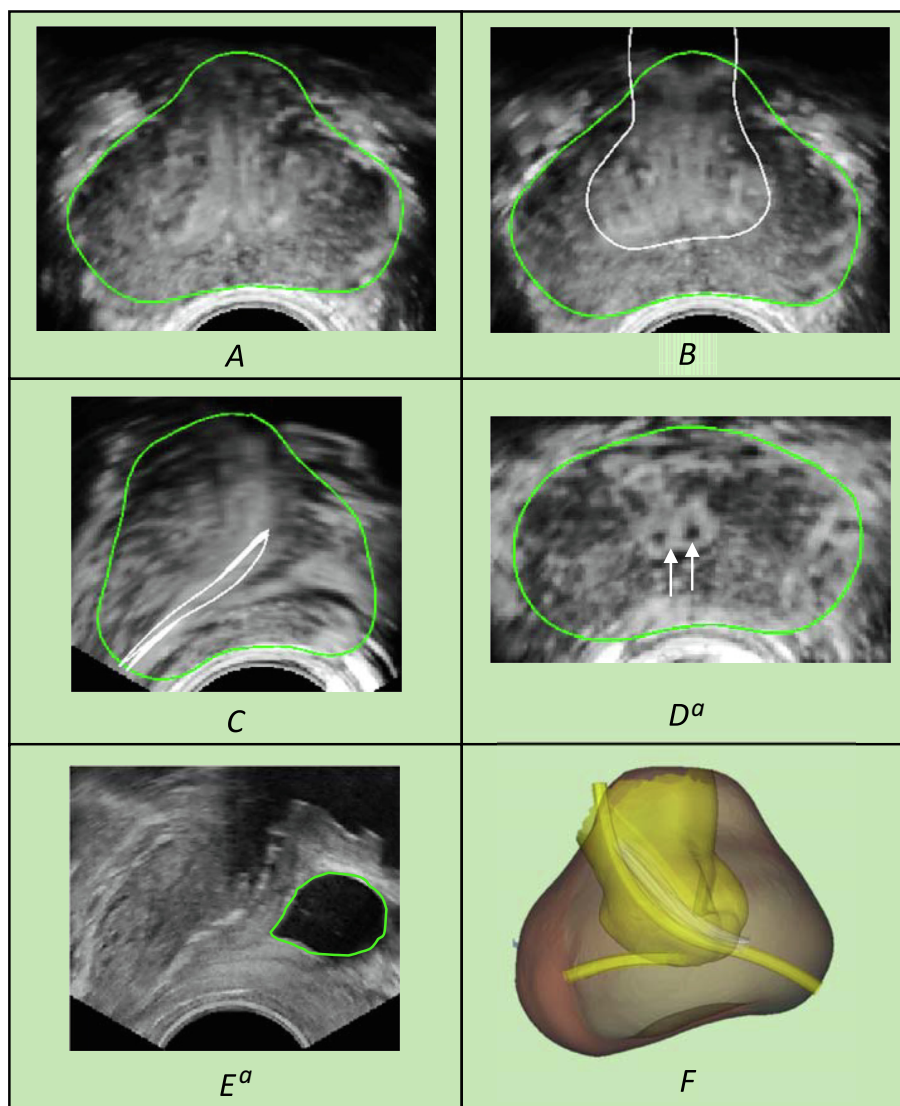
Ultrasound image segmentation. Images from a contrast-enhanced ultrasound from a single patient: (A) prostate border, (B) border between PZ and TZ, (C) urethra, and (D) ejaculatory ducts. (E) A brightness-mode ultrasound image from a different patient: example of a landmark (prostatic utricle cyst). (F) A 3D model of the prostate based on segmentation shown in (A–D). 3D = three dimensional; PZ = peripheral zone; TZ = transitional zone. ^a Ejaculatory ducts and landmarks can be used for more accurate registration, but are not visible for all patients.
